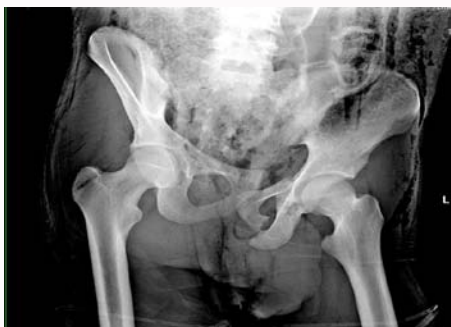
Anteroposterior pelvic X-ray of the patient at presentation.
